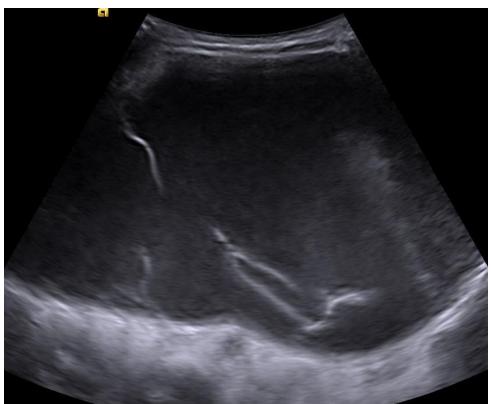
Ultrasound image showing cystic lesion with multiple septations and uniform low level internal echoes.
